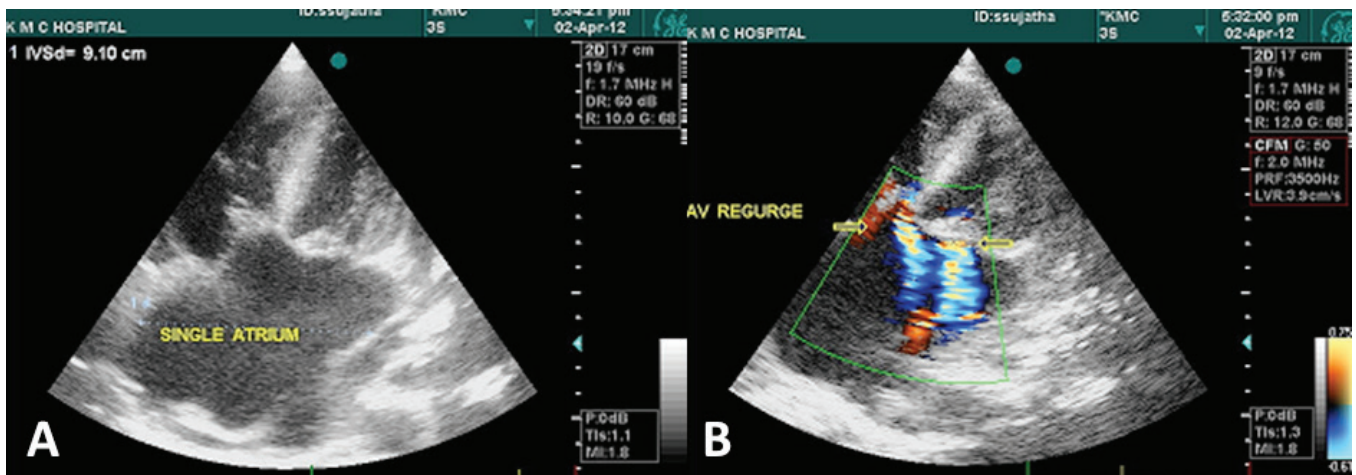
Echocardiography revealing – 4A. single atrium; 4B. mitral regurgitation.
